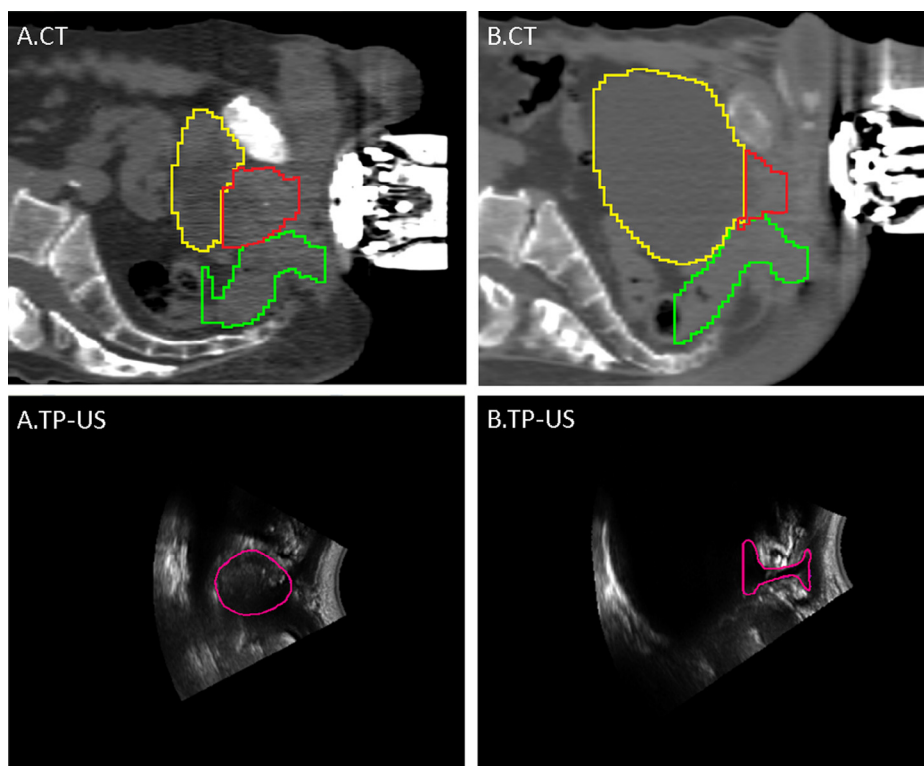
Sagittal slices of CT and TP-US images of prostate patients (respectively A.CT and A.TP-US) and of post-prostatectomy patients (respectively B.CT and B.TP-US). Red, yellow and green contours correspond to the CTV, bladder and rectum volumes, respectively, delineated on the CT image; pink contour corresponds to the RPV volume, delineated on the TP-US image.
